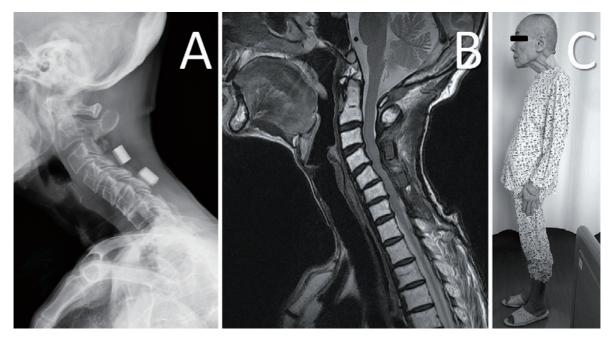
Images after first operation (cervical laminoplasty from C3 to C7). (A) X-ray at 10 months shows development of a cervical kyphotic alignment change combined with cervical disc degeneration. The loading axis of the head is shifted more anteriorly than shown preoperatively (CGH-C7 SVA, 75 mm). (B) Sagittal T2-weighted MRI shows recurrence of multilevel cervical cord compression despite the LAMP operation. (C) Photograph shows anterior shift of the head that demands sufficient power of the neck extensors to raise the head.
